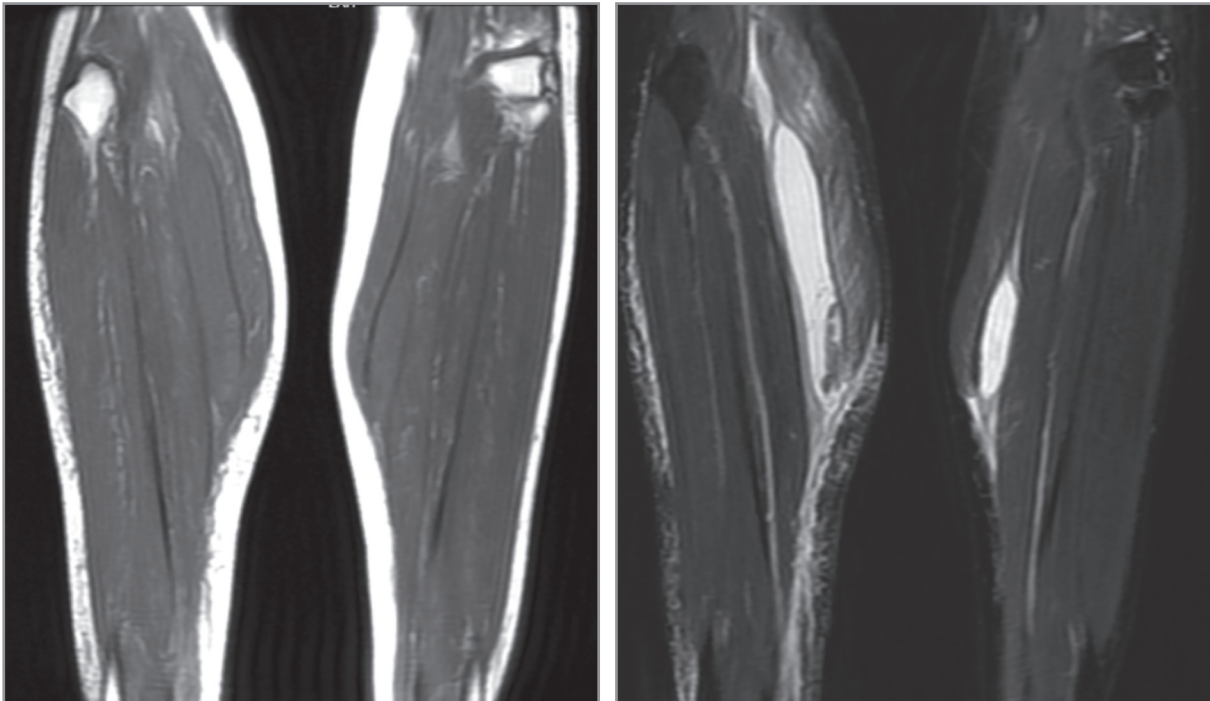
Coronal T1 and T2-weighted MR images showing a 13 cm measured hemoragic collection on the right side between gastrocnemius and soleus muscles with extensive peripheral fascial, muscular and subcutaneous fatty tissue edema. On the left side, on the same location a 6 cm measured pure cystic collection with mild peripheral edema are seen.
